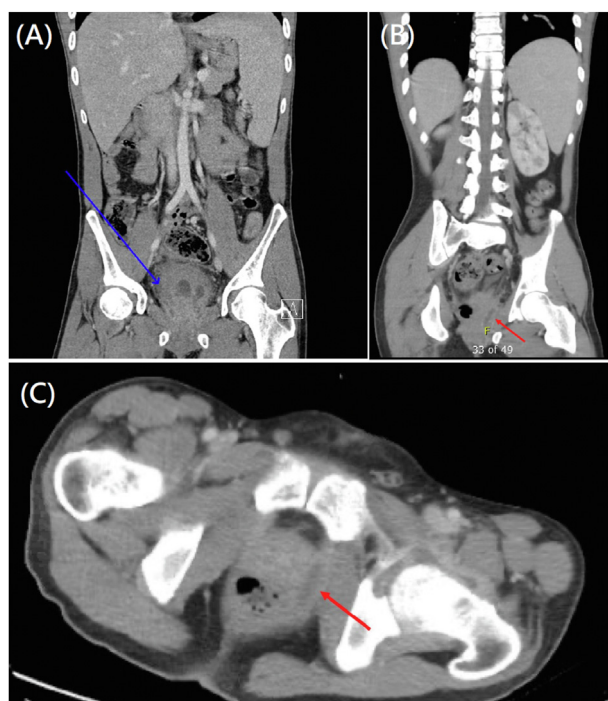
A: Computed tomography of the abdomen and pelvis revealing an abscess in the prostate at another hospital (arrow). B and C: Computed tomography of the residual abscess of the prostate on admission to this hospital (arrow).
